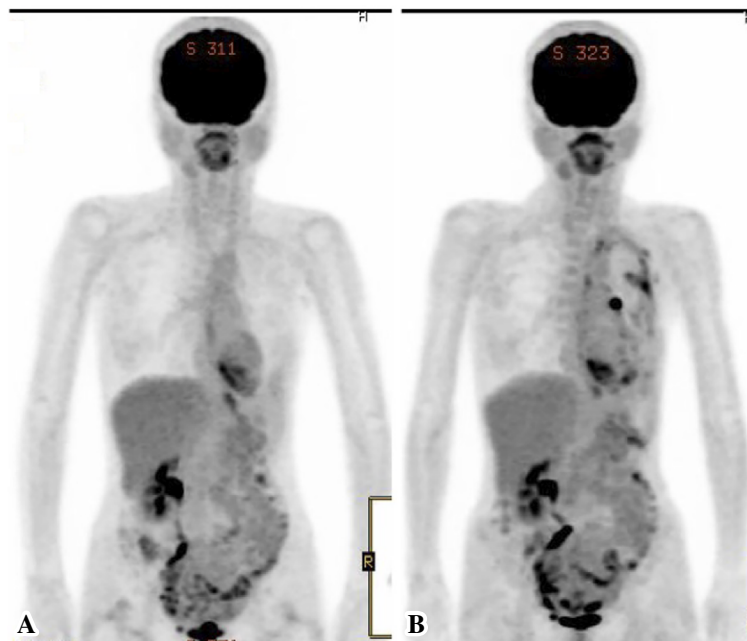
FDG-PET a year before the first visit to our hospital revealed no FDG uptake (A). FDG-PET at the first visit to our hospital revealed an FDG uptake in the left pleural cavity (B). FDG: ^{18}F -fluorodeoxyglucose, PET: positron emission tomography
